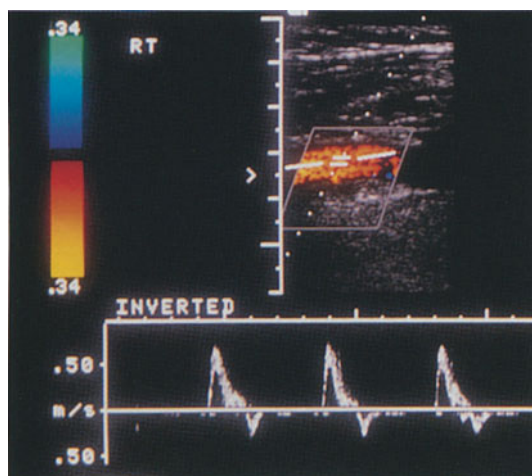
Normal subclavian artery with Doppler waveform: there is a steep systolic velocity upstroke (short acceleration time) followed by a short interval with reversed blood flow; the end-diastolic blood flow velocity is zero
